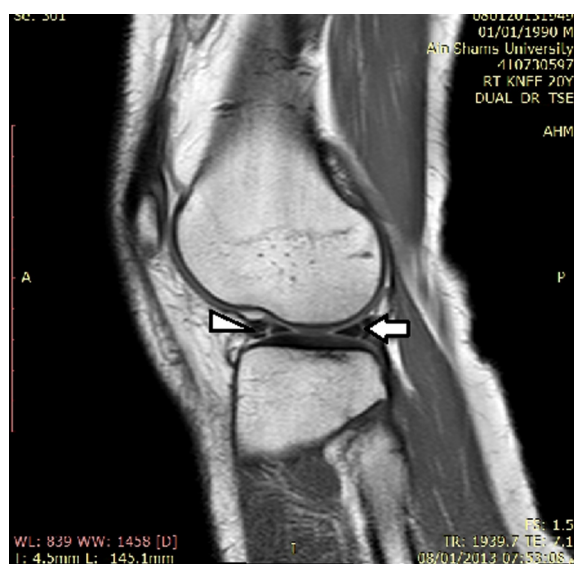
Sagittal T2W knee MR image demonstrating intra meniscal bright linear signal intensity of the posterior horn of medial meniscus reaching the superior and inferior articular surfaces (arrow) denoting post traumatic tears.
